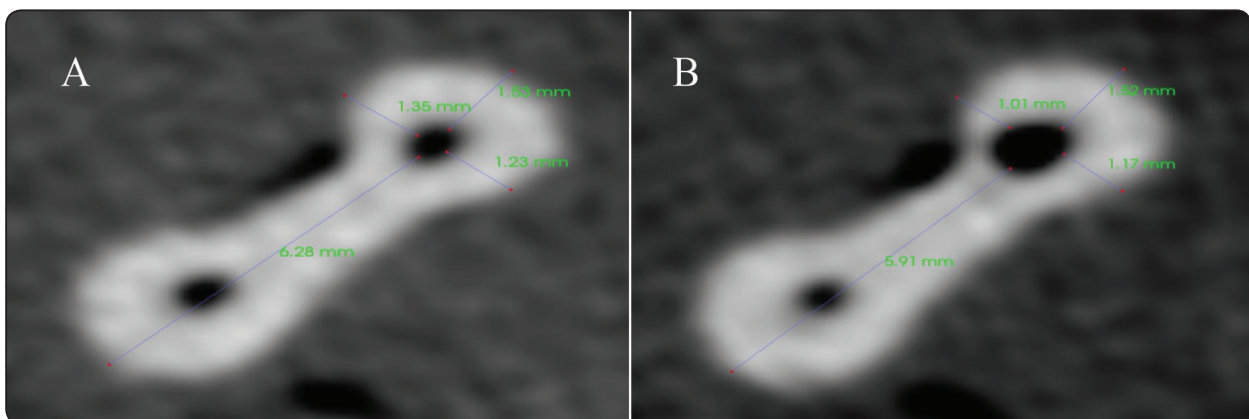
CBCT images at 8-mm distance from the apex; A) pre- and B) post-instrumentation images with Reciprocal CM. Amount of canal transportation was obtained from $(m1 - m2) - (d1 - d2)$ formula.
